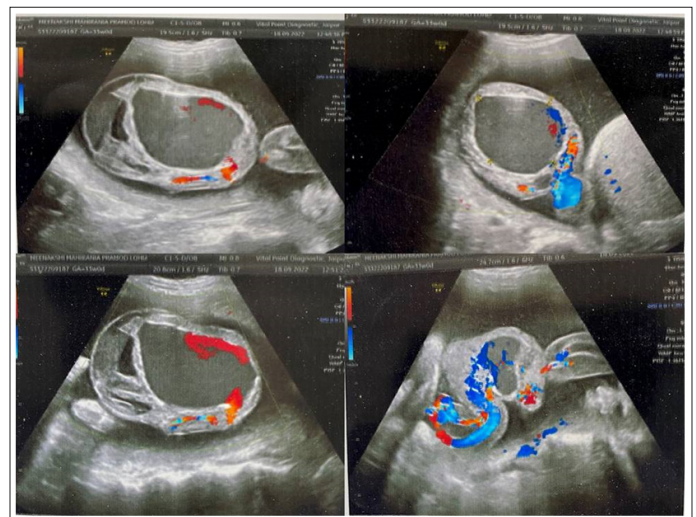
Doppler Image of Umbilical Artery Aneurysm
